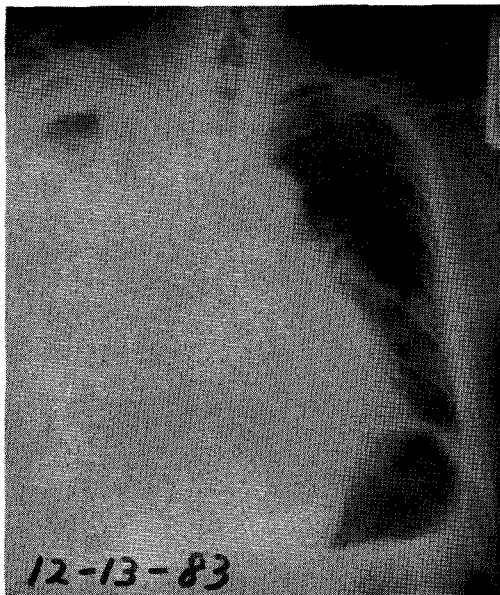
Pre-radiation chest X-ray of Case 1 shows pulmonary infiltration of lymphoma with right pleural effusion.
